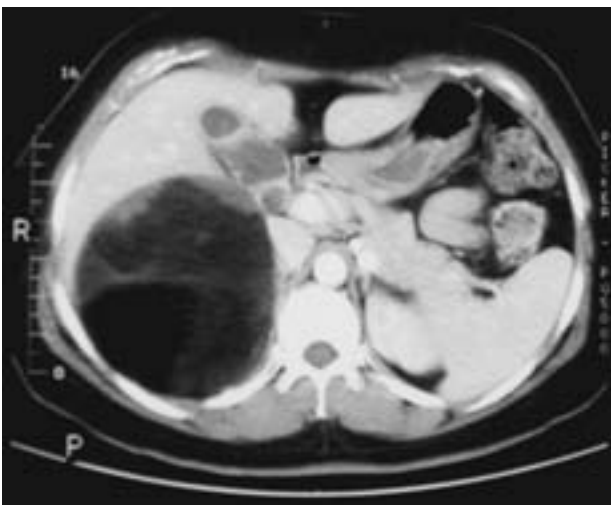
Abdominal CT scan in a 37-year-old woman who presented to our department with vague right abdominal discomfort of 4 weeks' duration. The large adrenal mass is composed mostly of fat with well-defined borders.
